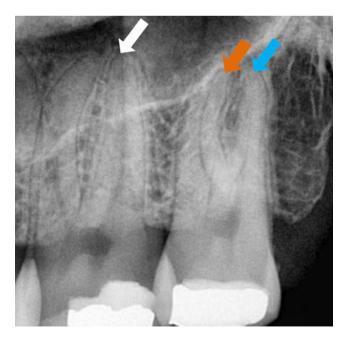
Cropped digital periapical image showing: Score 1 (Blue arrow), Score 2 (Orange arrow) and Score 3 (White arrow).
